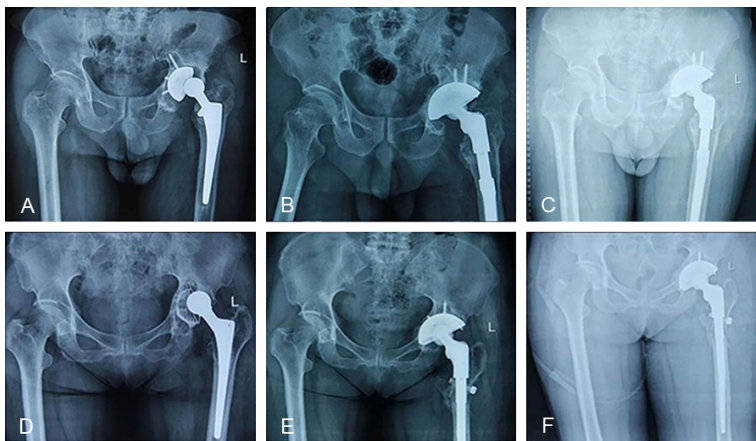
Typical X-ray characteristics of type IIA (A-C) and type IIIA (D-F) osteolysis at different stages. Radiographs taken in a 66-year-old man (A) before revision surgery and (B) 3 days and (C) 5 years after revision surgery. Radiographs taken in a 68-year-old woman (D) before revision surgery, and (E) 2 days and (F) 3 years after revision surgery.
